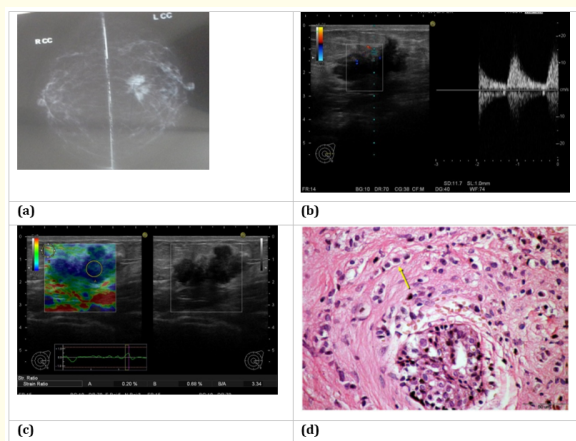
55 years female with palpable left breast lump. (a) Mammogram (CC view) showed dense opacity with irregular outlines in the inner quadrant from the left breast. (b) conventional US showed hypoechoic lesion with irregular borders, posterior acoustic shadowing with detected vascularity on color Doppler. (c) elastography of the lesion showed score 4 (the lesion was uniformly blue color signature confined to the visible margin of the lesion) and strain ration 3.3 (d) FNAC of the mass revealed infiltrating ductal carcinoma with small hyperchromatic cells around proliferating ducts.
